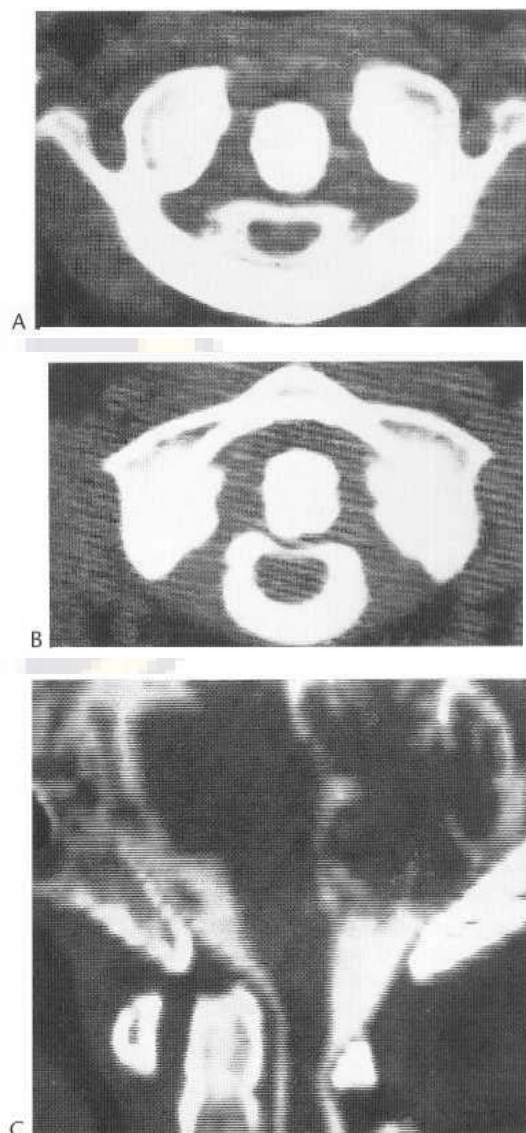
Rheumatoid arthritis with atlanto-axial subluxation. (A,B) CT axial sections at level of the atlas. (C) Midsagittal reformatted section. There is erosion of the odontoid peg and anterior subluxation of the atlas; the spinal cord is compressed by the odontoid peg and posterior arch of the atlas.
